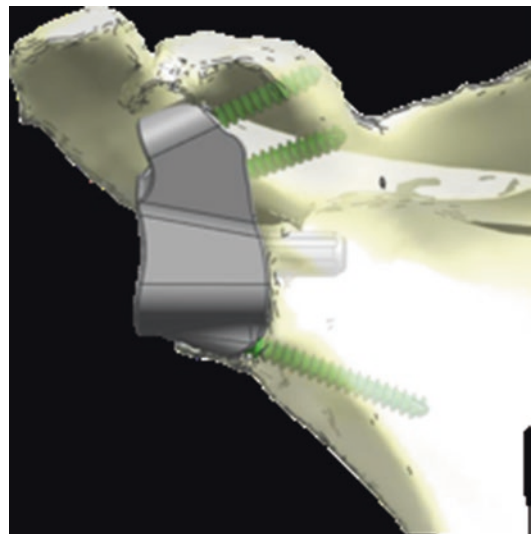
Custom-made implants should be considered a salvage option in CTA or in revision after failed RSA with severe bone loss
